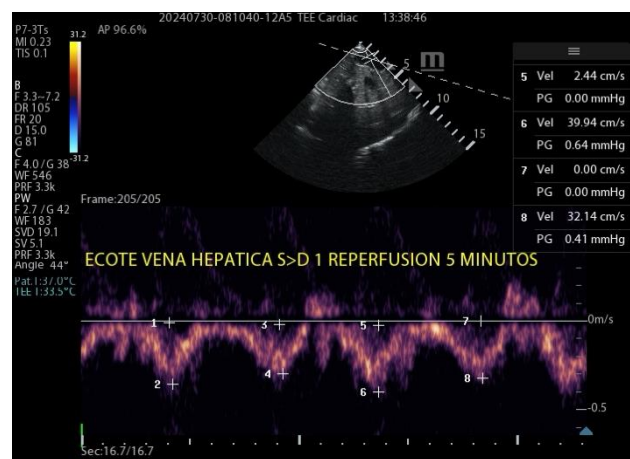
Hepatic Vein Doppler at 5th minute reperfusion in the kidney transplant patient.
